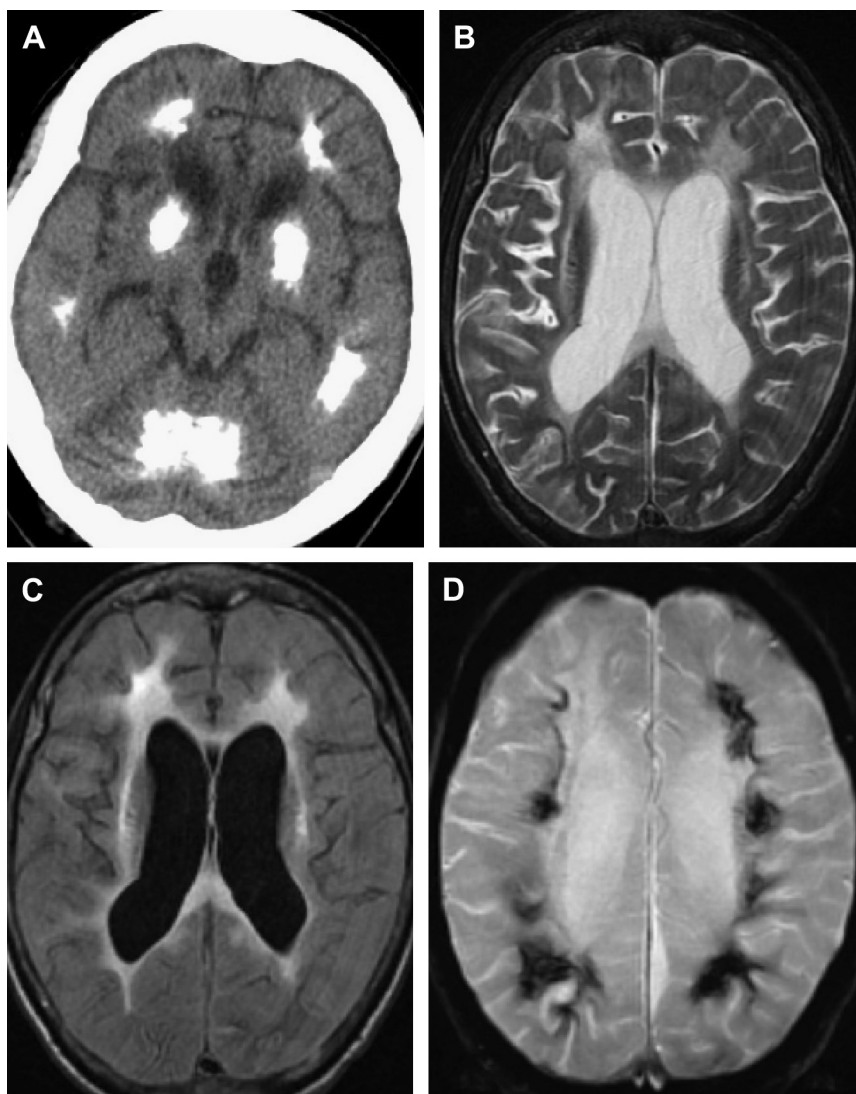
Twenty-eight year old with Cockayne syndrome. Computed tomography of the head (A) demonstrates homogeneous coarse calcification of the basal ganglia, cerebral white matter, and cerebellar white matter. MR imaging of the brain demonstrates volume loss with central white matter signal increase on the axial T2 (B) and FLAIR (C) sequences. The T2* gradient recalled echo sequence (D) also demonstrates white matter calcification.
